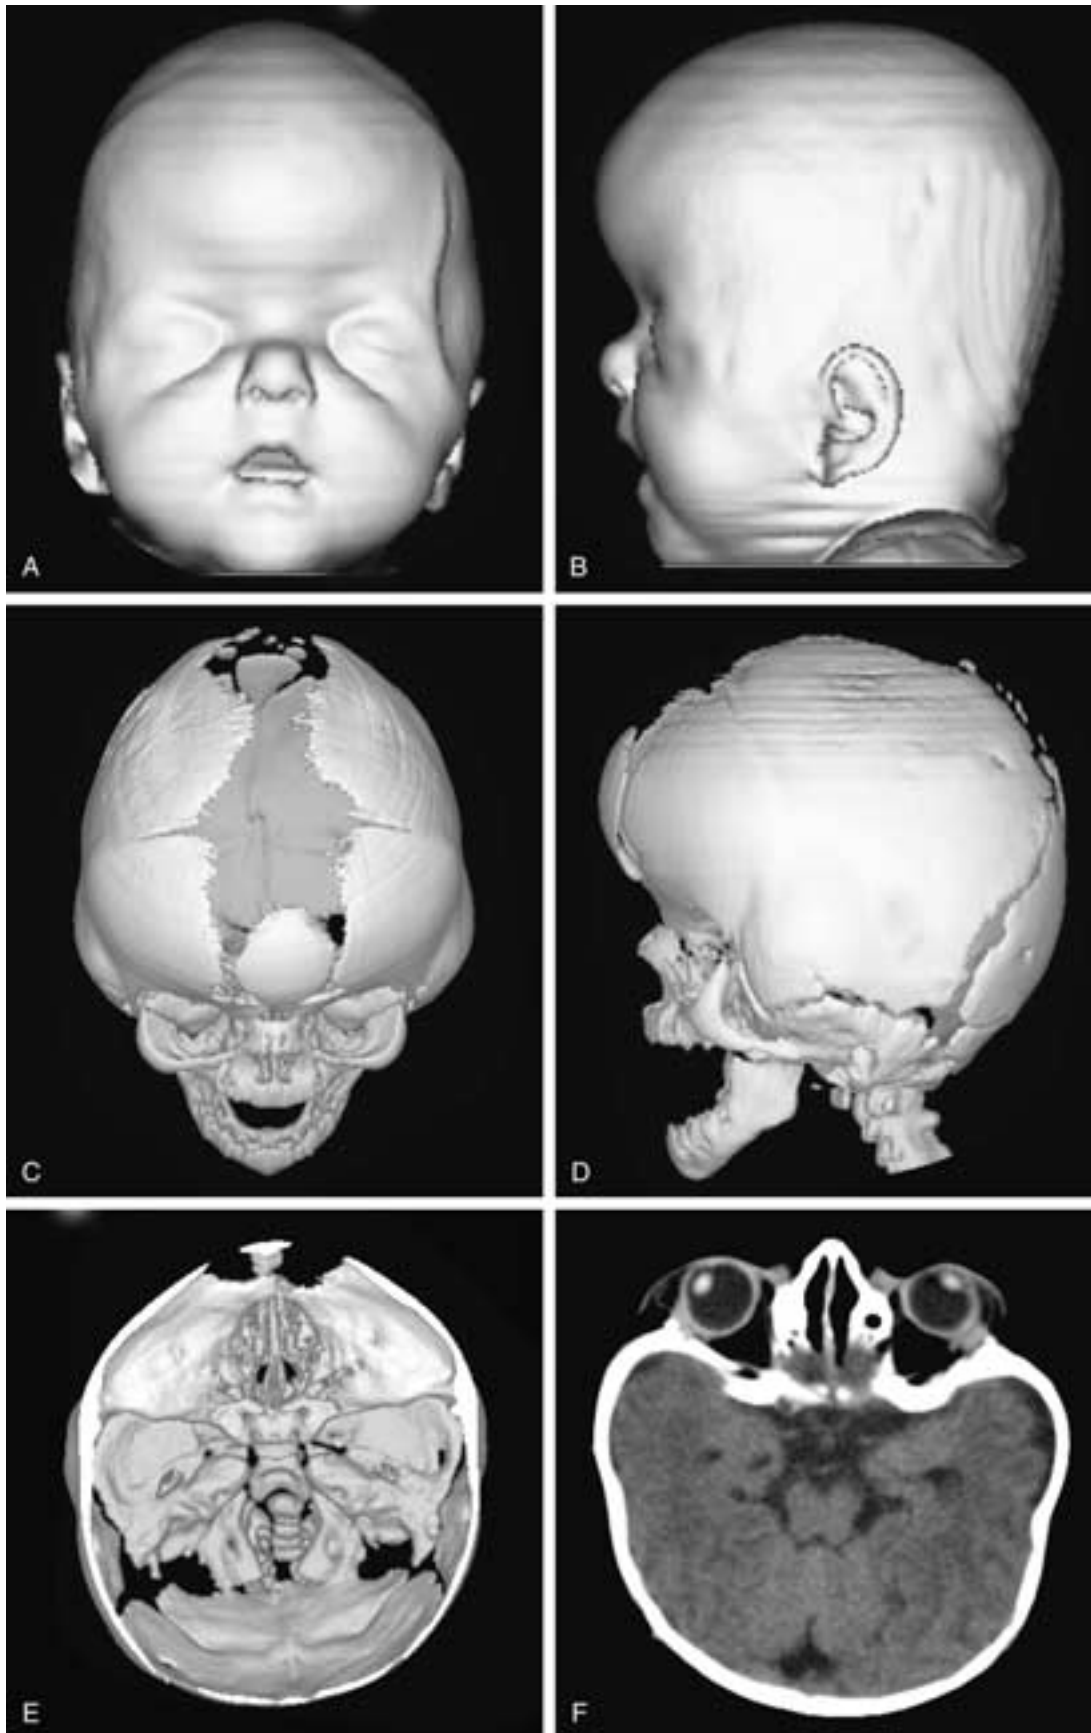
Apert syndrome in an infant boy. A to D, Three-dimensional CT displays of the frontal (A) and lateral (B) skin surfaces, and the corresponding frontal (C) and lateral (D) facial skeletons. E and F, Three-dimensional CT of the skull base (E) and an axial CT section through the orbits (F). The patient shows brachycephaly with fused coronal sutures bilaterally, wide patency of the sagittal suture, metopic suture and anterior fontanelle with an intrasutural bone, consequent hypertelorism, shallow symmetric anterior fossa, and midface hypoplasia with marked exorbitism.
